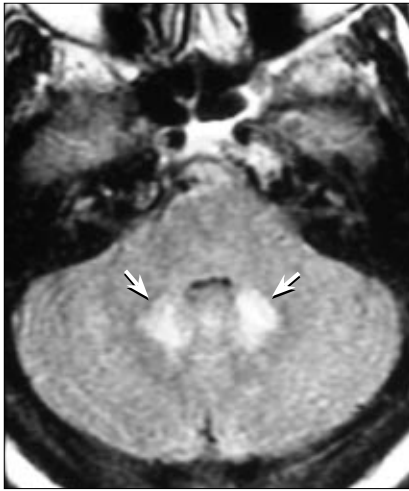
Axial FLAIR MR image demonstrates hyperintense signal in the dentate nuclei of the cerebellum.
